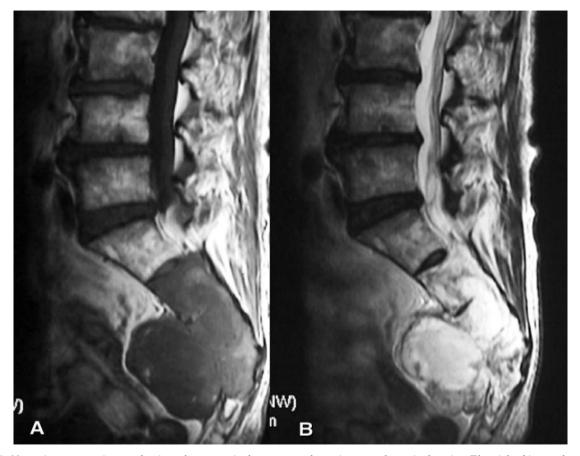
Magnetic resonance images showing a huge mass in the sacrum and anterior area of a sagittal section. T1-weighted image shows a low-intensity mass (A). T2-weighted image shows a high-intensity mass involving the S2 posterior sacral body (B).
